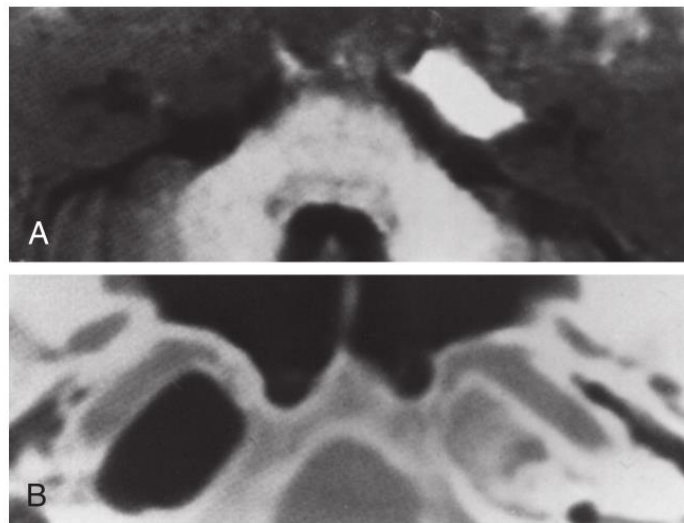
Asymmetric pneumatization of the petrous apex demonstrated on an axial T1-weighted image (A) and an axial computed tomography scan (B). Note that the area of hyperintensity on the T1-weighted image could be confused with a neoplasm. The computed tomography scan reveals extensive pneumatization on the contralateral side and limited pneumatization on the side with hyperintense signal on magnetic resonance imaging.
